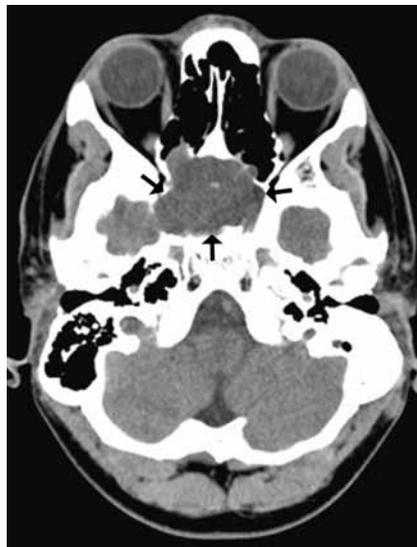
Note slightly hypodense mass (arrows) involving the sphenoid sinus area on this transverse non contrast enhanced CT image (soft tissue algorithm).
